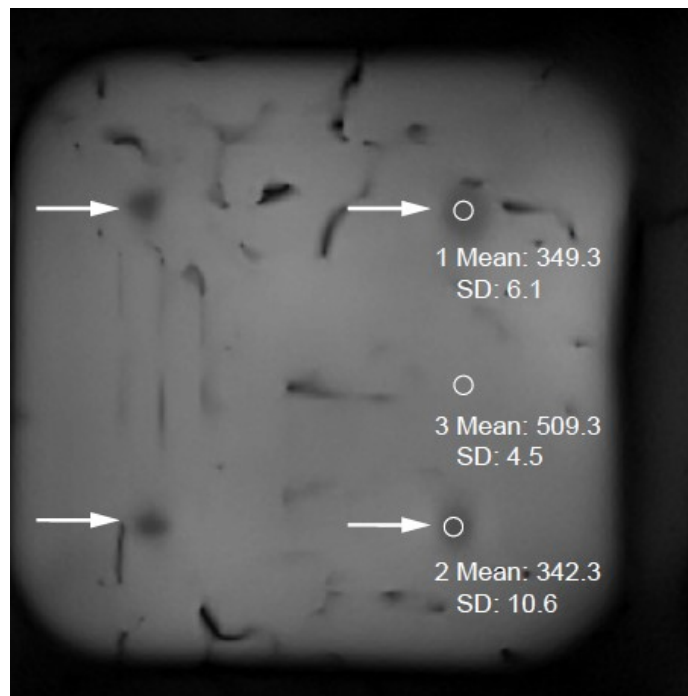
Cross-section through the volumetric MRI image. Four shadow-like regions can be observed at the intended inclusion positions.
